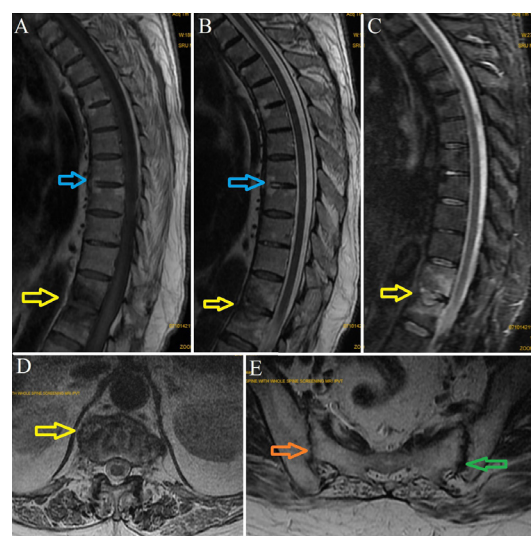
MRI showing classical features of Andersson lesion (yellow arrows) in D11–D12 of hemispherical shaped lesion, which is hypointense on (A) T1 weighted sequences, hyperintense on (B) T2 weighted sequences and (C) STIR sequences. Modic II changes (blue arrows) being hyperintense on T1 and T2 sequences are noted in D4, D5, D7 and D8 vertebra. (D) Axial section showing vertebral end plate erosions, irregularity and reactive sclerosis. (E) SI joints showing decreased joint space (orange arrow) and subchondral erosions (green arrow). STIR, short tau inversion recovery.
